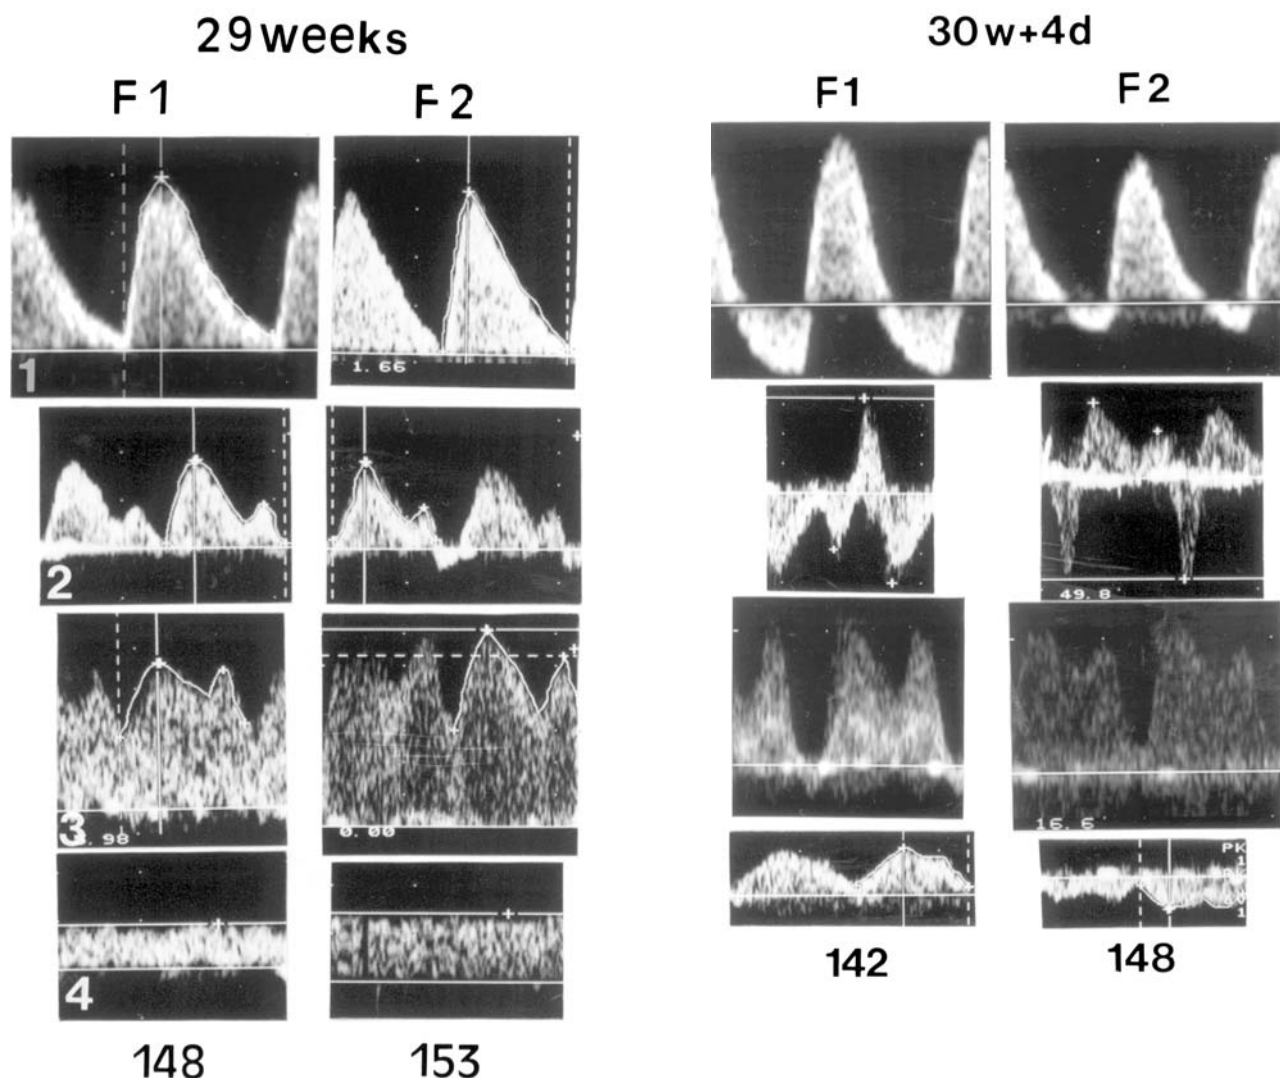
Doppler blood flow waveforms from umbilical artery (1), inferior vena cava (2), ductus venosus (3) and umbilical vein (4) obtained in fetuses F1 and F2 of a dichorionic diamniotic twin pregnancy. The first examination was performed at 29 weeks with present end-diastolic flow in the umbilical artery and normal venous flow. The scan performed at 30 weeks +4 days, on the day of the elective delivery, shows reverse end-diastolic flow in the umbilical artery, with a high velocity A-wave in the inferior vena cava, absent flow during the atrial contraction in the ductus venosus and dichroic pulsatile flow in the umbilical vein in both fetuses. Both babies are alive and well, but were born growth-restricted. Reproduced with permission from *Journal of Perinatal Medicine*.
